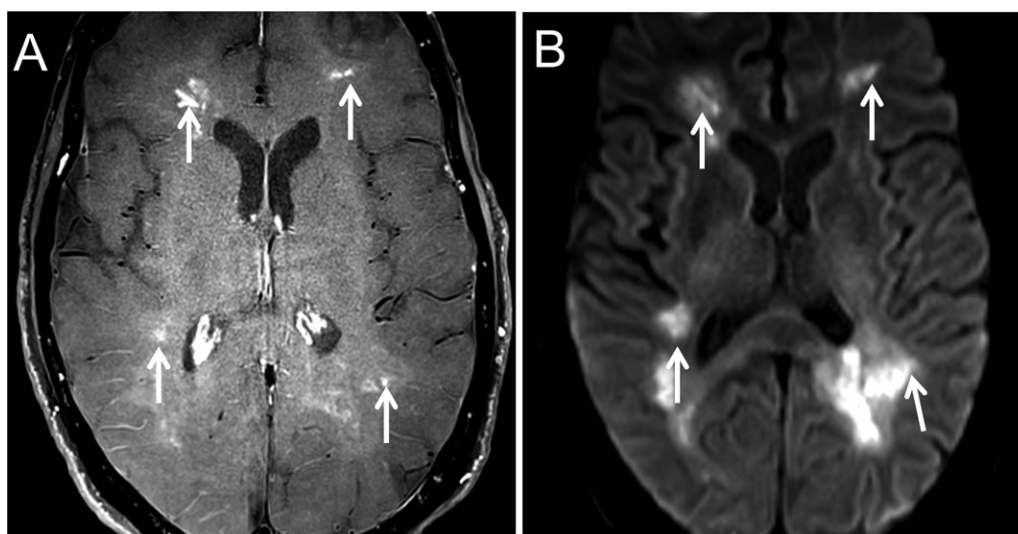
Parenchymal enhancement from subacute ischemic stroke mimicking vasculitis in a 63-year-old woman with a history of intravascular lymphoma. (A) Postcontrast vessel wall (VW) MRI scan shows patchy parenchymal enhancement, some with a linear configuration, in the frontal and parietal lobes (arrows). (B) Enhancement corresponds to foci of restricted diffusion (arrows) on diffusion-weighted images.
